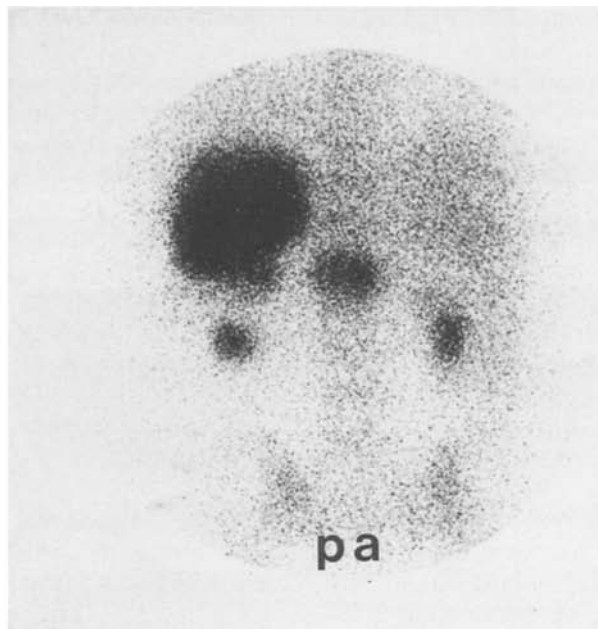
^{111}In -labelled leucocyte scan in a patient undergoing regular dialysis treatment and with a 2-day history of leucocytosis, fever and back pain. The scan demonstrates infection of both kidneys and osteomyelitis of the spine. Ultrasonography of the kidneys and X-ray of the spine were not suspicious but became positive 15 days after the first clinical symptoms
